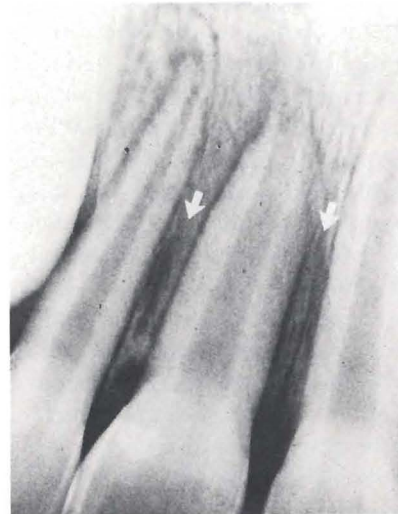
Postorthodontic radiograph in November 1982, showing presence of radiopacity with a halo of radiolucency.
